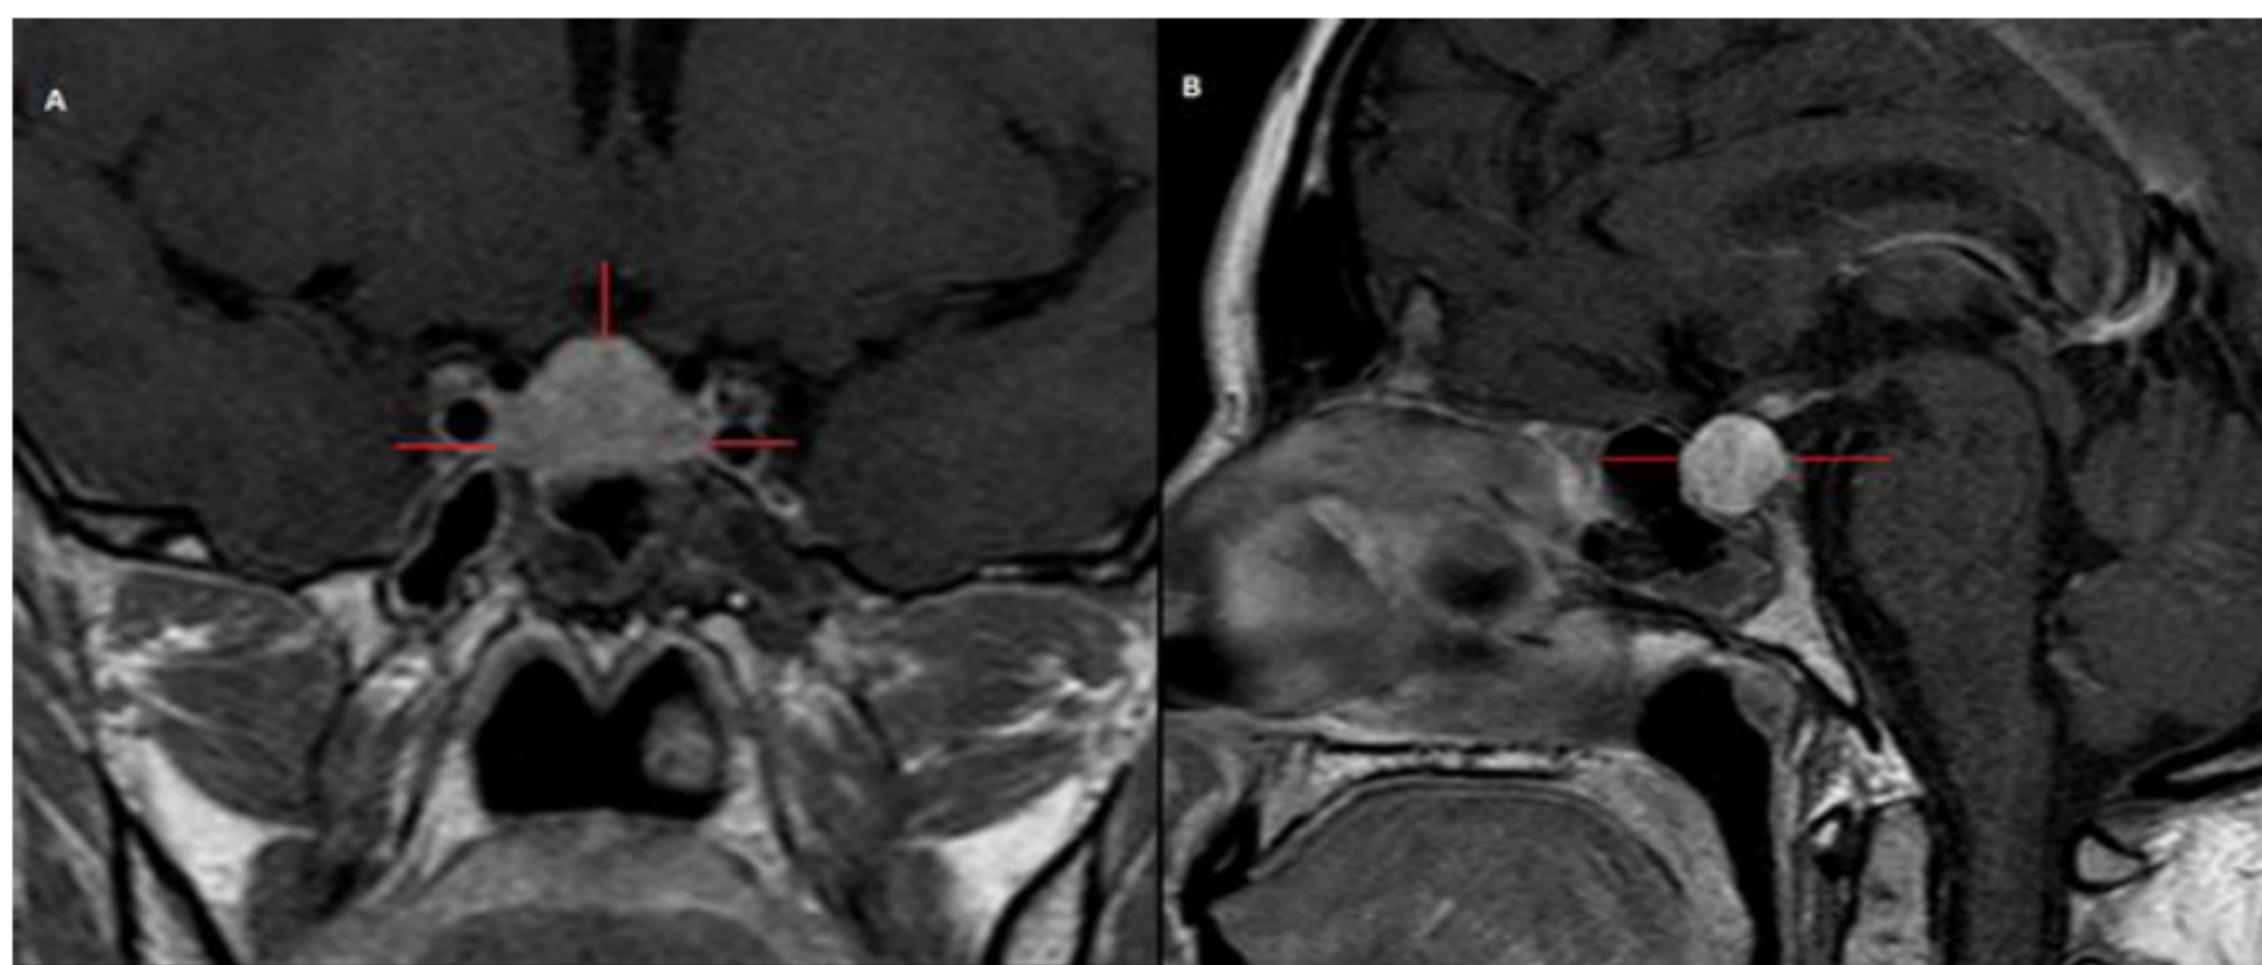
Pretreatment MRI of the pituitary gland. Post-contrast T1-weighted coronal (A) and midsagittal (B) images shows marked contrast enhancement of thickened pituitary gland.
